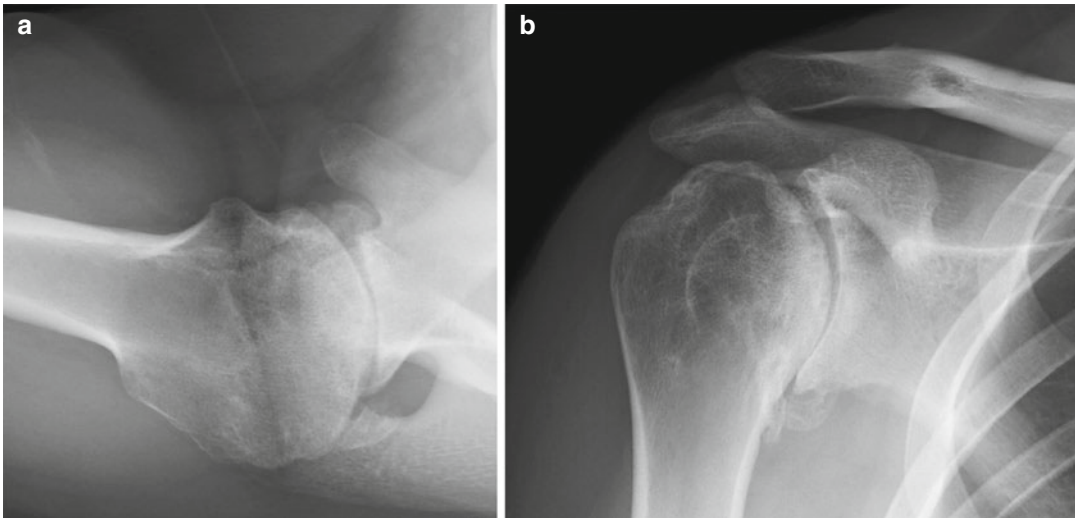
Right shoulder preoperative (a) axillary and (b) Grashey radiographs of a 32-year-old man with severe osteoarthritis after developing chondrolysis from an arthroscopic surgery performed at age 16
